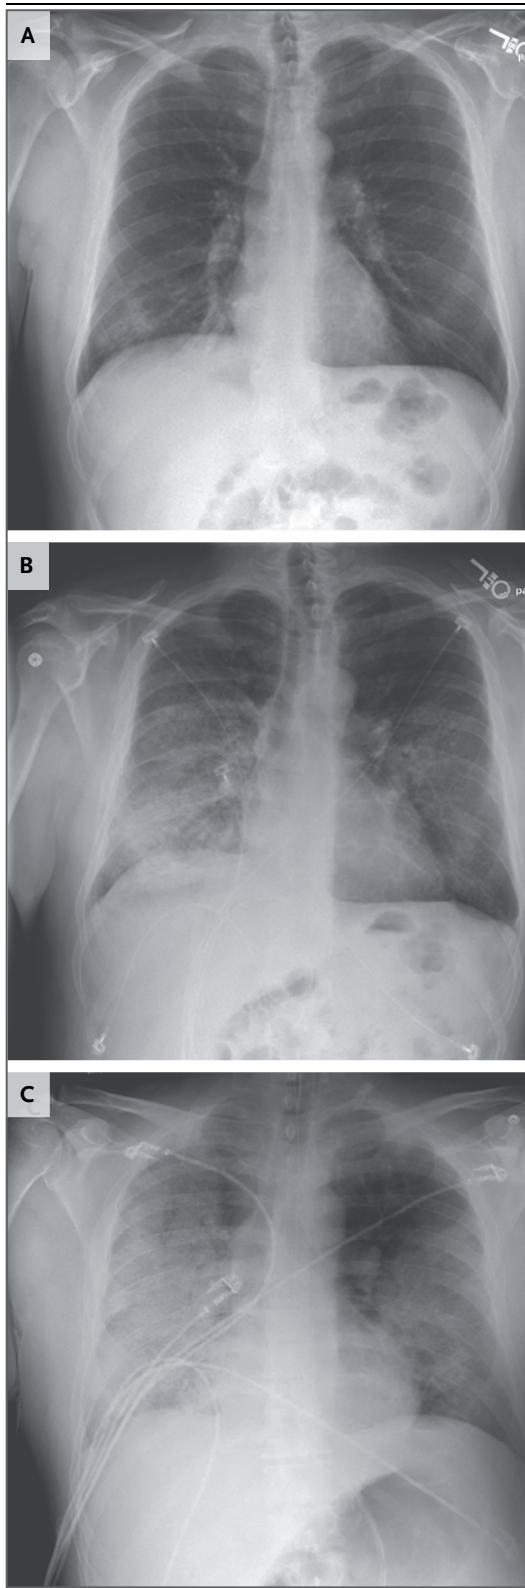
Serial Radiographs of the Chest.
